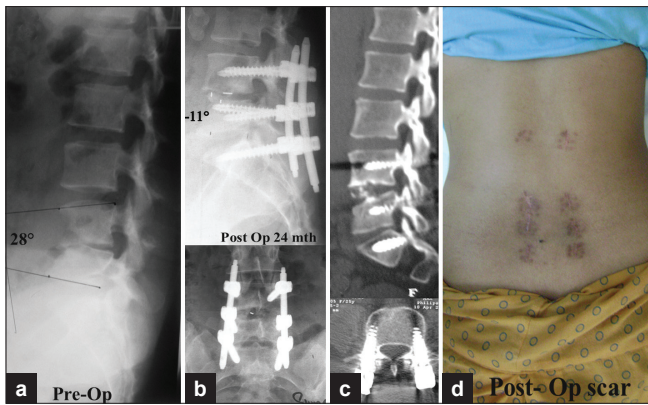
A 24 year old female with TB spine L4-L5 with progressive kyphosis and left L4 and L5 radiculopathy. (a) Preoperative lateral X-ray showing decreased disc space L4-5 with segmental kyphosis. (b) postoperative X-rays (AP and Lat) shows restoration of lumbar lordosis. (c) CT scan sagittal and axial cuts showing good placement of screws with inter-body fusion. (d) Clinical photograph displaying the scars
